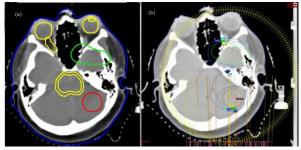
(a) contours for PTV1 (green), PTV2 (red) and OARs (yellow) on a real CT transverse slice.(b) Isodoses and VMAT arcs for the same slice.
